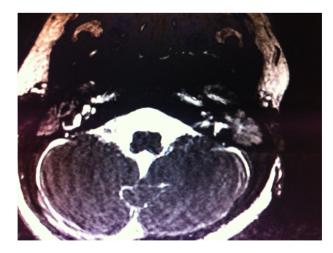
MRI, T2-weighted sequence, axial section of the petrous temporal bones of patient 5: partial extinction of the T2 hyperintensity of the endolymph of the left cochlea suggesting cochlear ossification or fibrosis.
